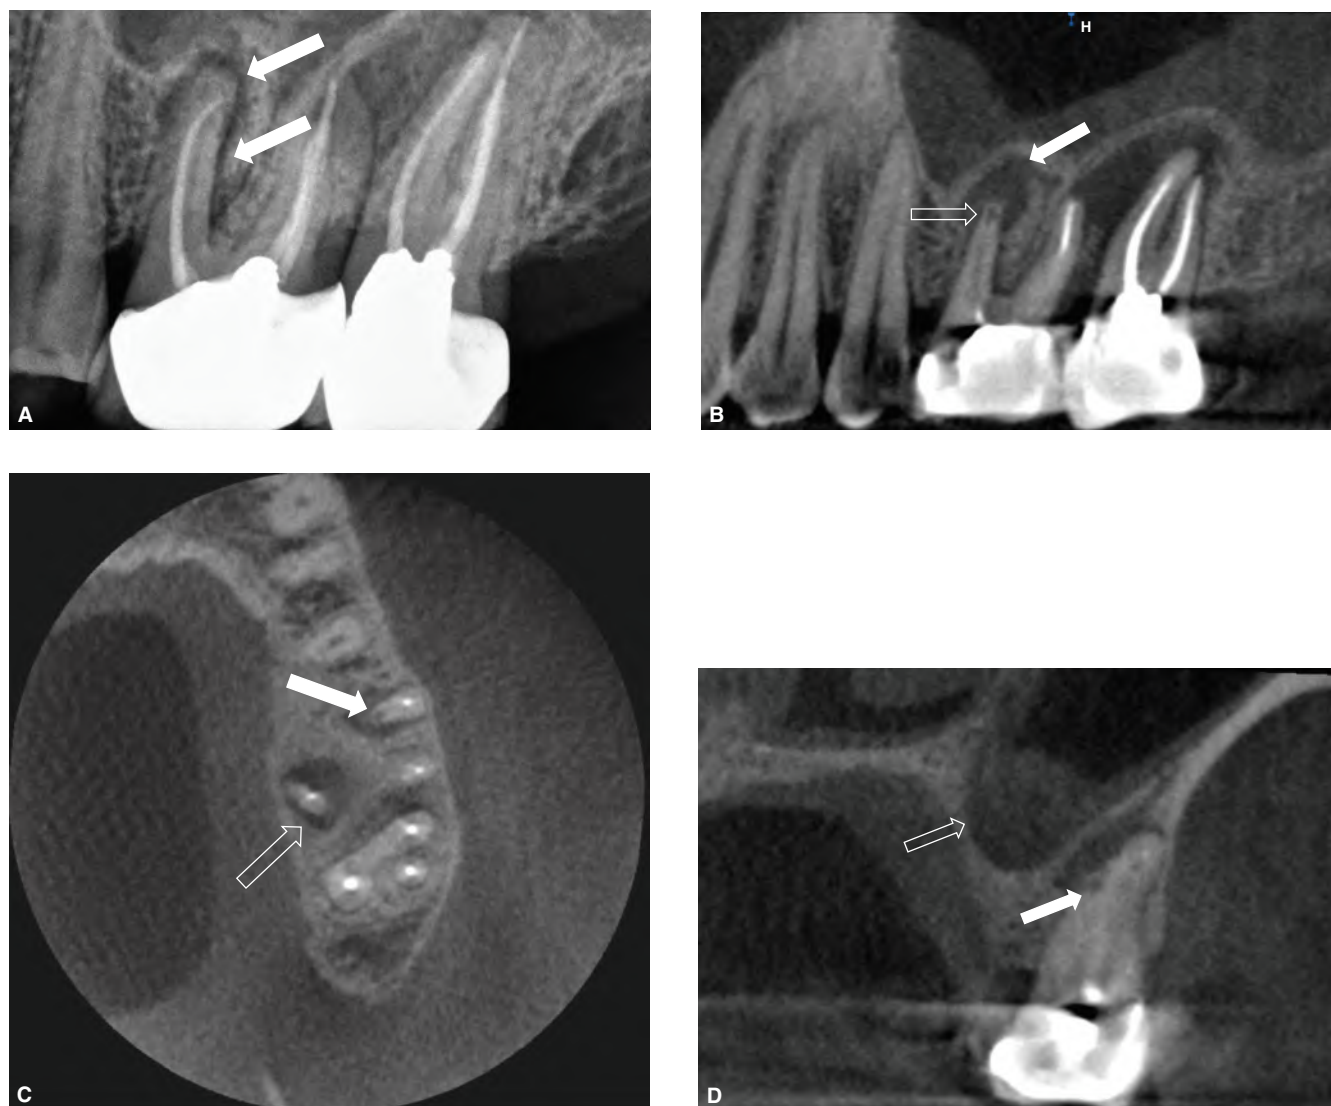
6 Periapical radiographs can be suboptimal in representing complex anatomy compared with CBCT. A. Periapical radiograph of an endodontically treated maxillary molar is consistent with mesiobuccal root apical periodontitis continuous with a furcal defect (solid arrows). This first molar also evidences PDL widening distal to the distal root. The second molar has features consistent with apical periodontitis of the palatal root and widening of the PDL space anterior to the mesiobuccal root. B. CBCT sagittal reformation, left maxillary first molar shows features consistent with chronic periradicular abscess at the mesiobuccal root (solid arrow), continuous with a furcation defect. There is an untreated mesioaccessory canal and internal resorptive defect at the periapex not visible on the periapical radiograph (open arrow). The left maxillary second molar has features consistent with a large, periradicular abscess continuous with a furcation defect and periradicular periodontitis along the distal aspect of the distobuccal root extending to the distobuccal apex. The maxillary sinus within the CBCT image has features consistent with chronic sinusitis. C. CBCT axial reformation, left maxillary first molar has features consistent with a chronic periradicular abscess at the mesiobuccal root and also has an untreated mesioaccessory canal. Note internal resorptive defect at the periapex (solid arrow) and features consistent with chronic periradicular abscess at the palatal root (open arrow). There is a mucositis of the floor of the maxillary sinus overlying both the left maxillary first and second molars, and these teeth show radiographic features consistent with advanced periapical periodontitis along the mesial aspect of the mesiobuccal root and early periradicular periodontitis at the palatal root. D. CBCT corrected axial reformation shows radiographic features consistent with a chronic periradicular abscess at the palatal aspect of the mesiobuccal root. The subjacent floor of maxillary sinus shows radiographic features consistent with a mucositis (open arrow). There is an internal resorptive defect at the periapex of the mesioaccessory root (solid arrow).
